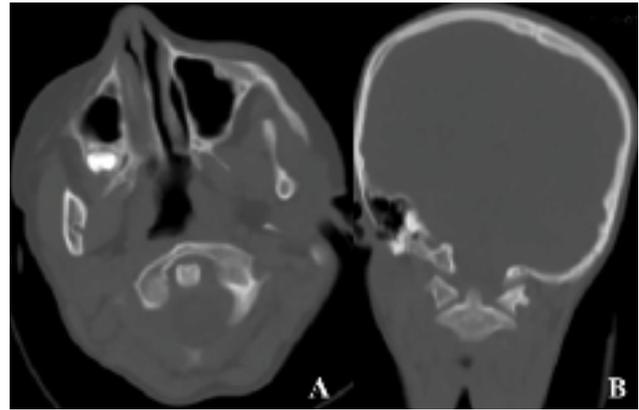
A. Axial, B. Coronal reconstructed cervical CT scan demonstrating the rotation of atlas on the odontoid with no anterior displacement
